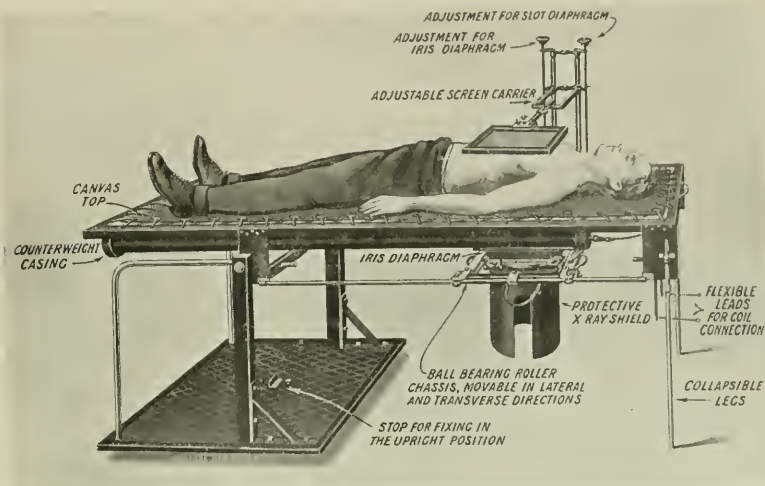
Grevillite combined screening stand and X-ray couch. (Medical Supply Association.)
